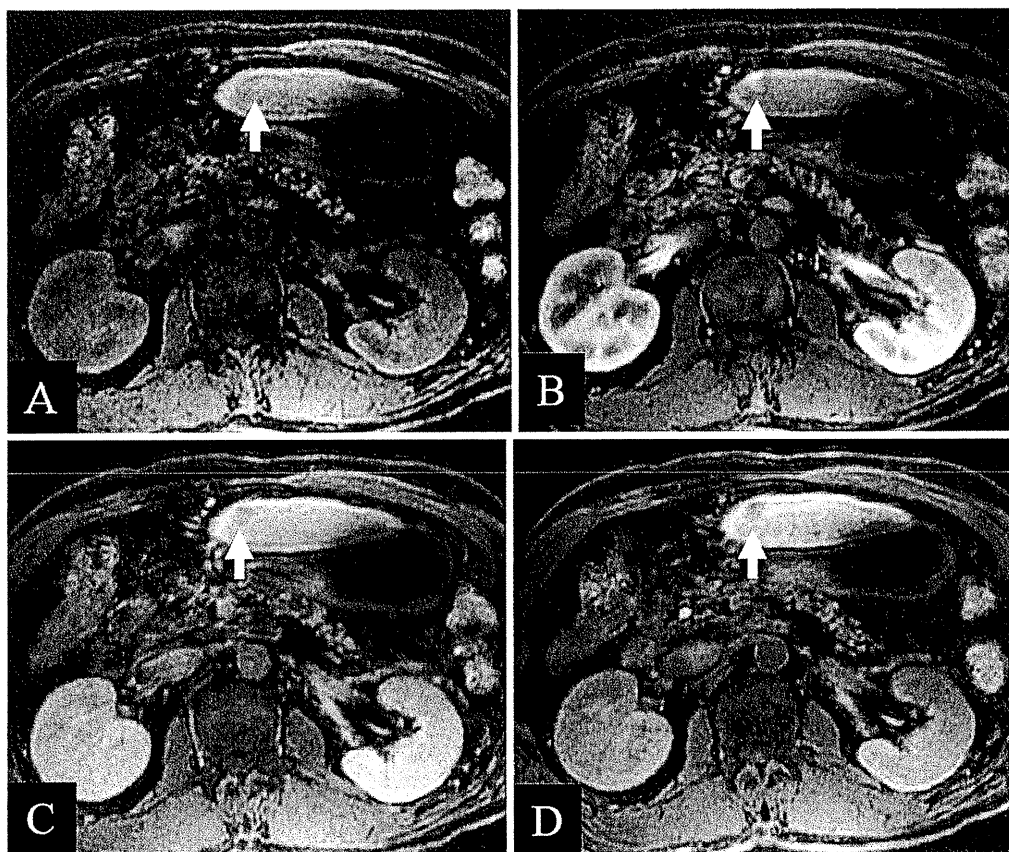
Images of the FNH-like nodule in segment 3 in Gd-EOB-DTPA-enhanced MRI. Arrows indicate a 9mm FNH-like nodule. (A) Low signal intensity before contrast injection, (B) High signal intensity during the hepatic arterial phase, (C) Washout pattern during the equilibrium phase, (D) Low signal intensity during the hepatobiliary phase.
